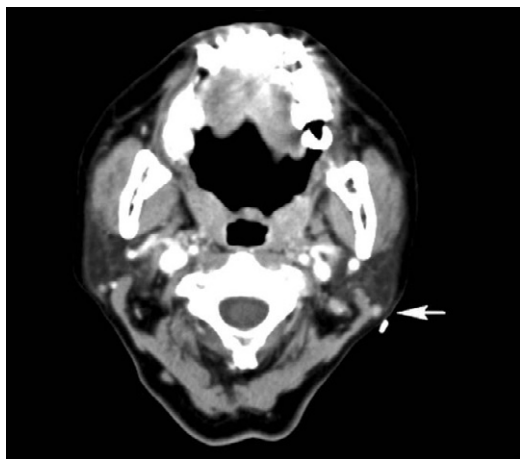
Computed tomography scan with contrast revealed an intraparotid lymph node (arrow).
